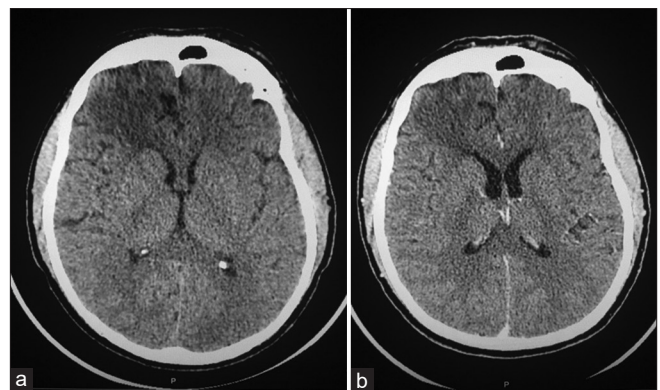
(a) Axial CT scan without contrast and (b) post contrast axial CT scan showed right frontal lobe hypodensity.
